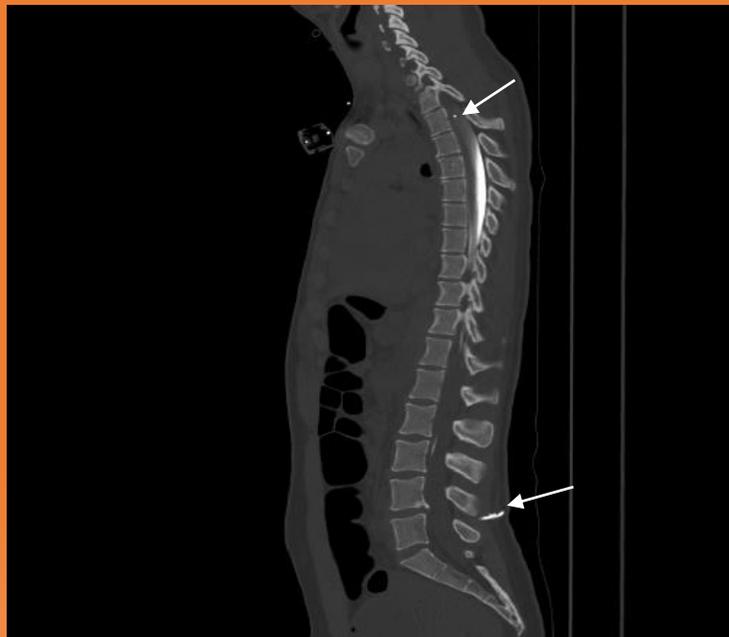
CT myelogram shows catheter entering spinal canal at L4-5 and coursing along epidural space until approximately T12 where it enters the thecal sac then extends cephalad to level of T3
